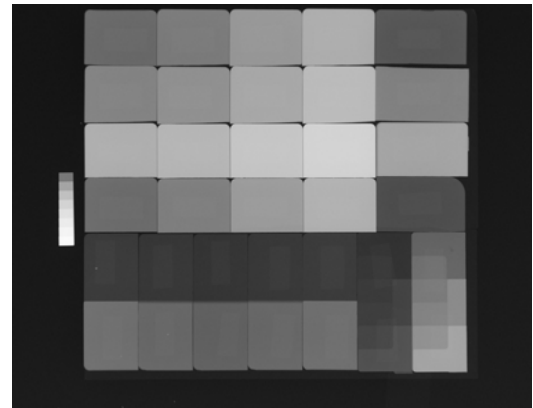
Image of samples studied with Kubtec X-ray unit for evaluating radiopacity. Lighter = more opaque. Aluminum step-wedge shown at left.
